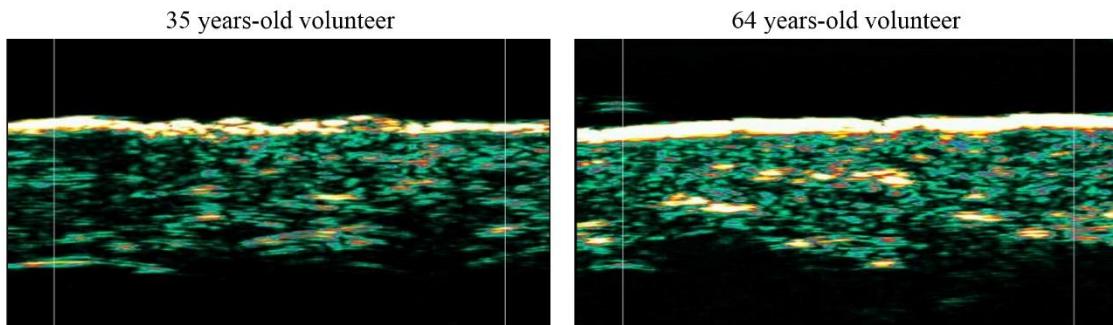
Example of ultrasound echography with a 50 Mhz probe
